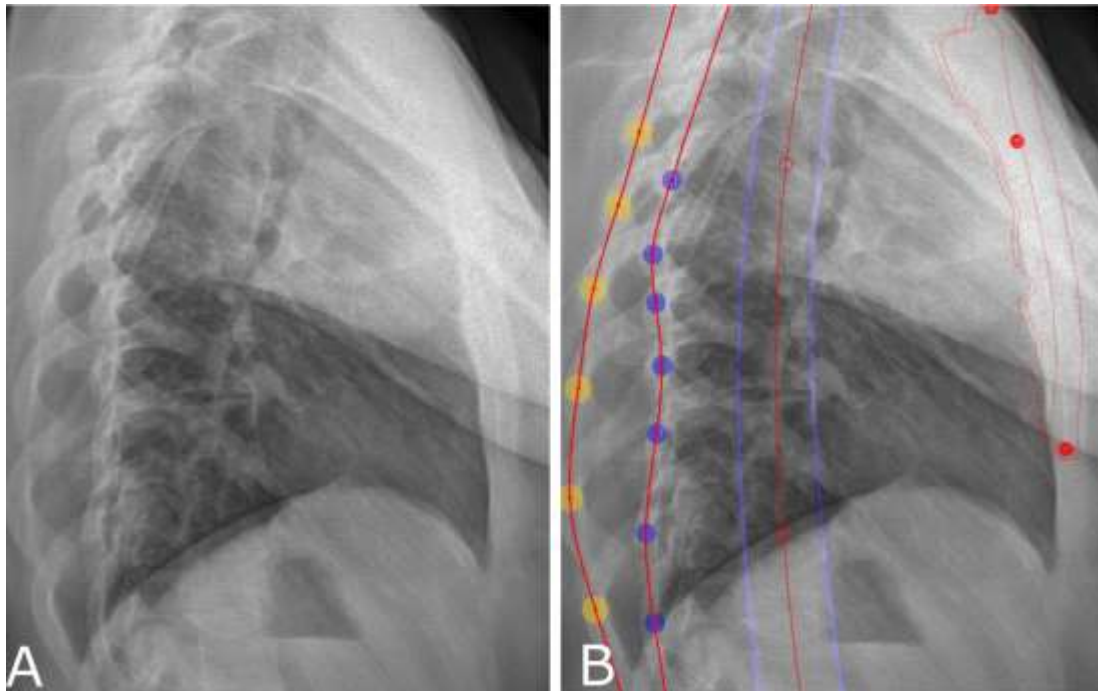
(A) original lateral x-ray and (B) ribs posterior extremities identified by two sets of round spots. The centroids of each set of spots were connected by cubic splines, representing the dorsal left and right extremities of the rib cage. The template representing the sternum and the spinal midline are also visible
